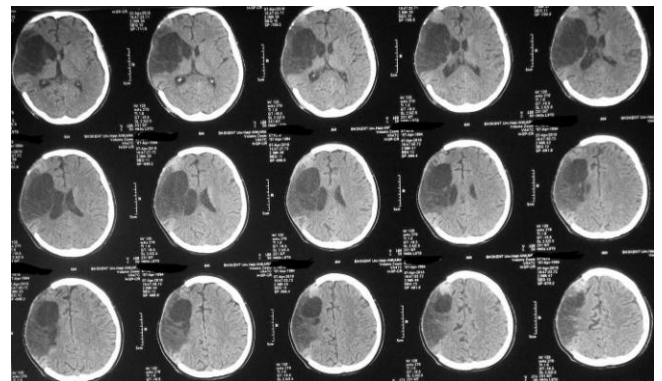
Axial CT shows the large cystic encephalomalacic region that was supplied by the right MCA before the embolic stroke, and no signs of elevated intracranial pressure. Both lateral ventricles appear symmetrical and there is no midline shift. In addition, the defect in the craniectomy region is seen.
